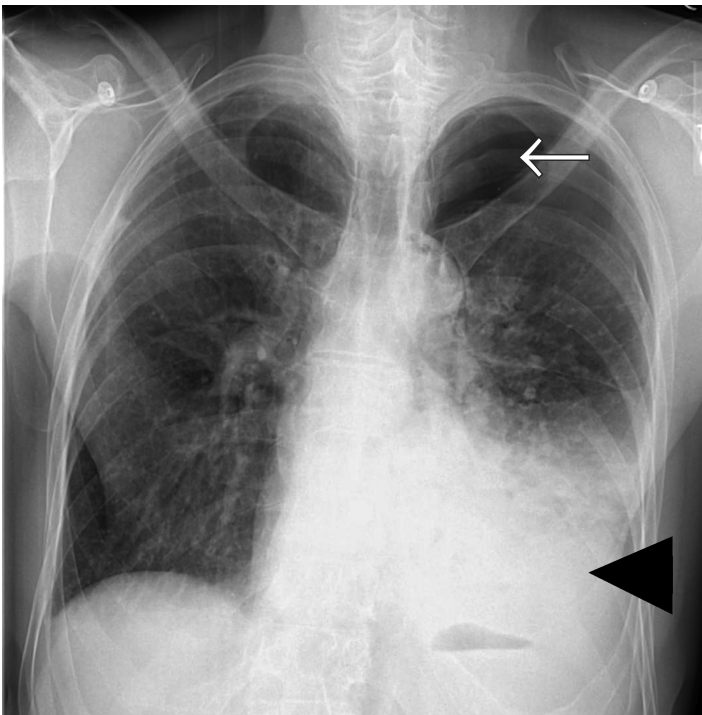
Radiograph of left-sided pneumo-hydrothorax, where the black arrowhead indicates the hydrothorax and the white arrow indicates the pneumothorax.
